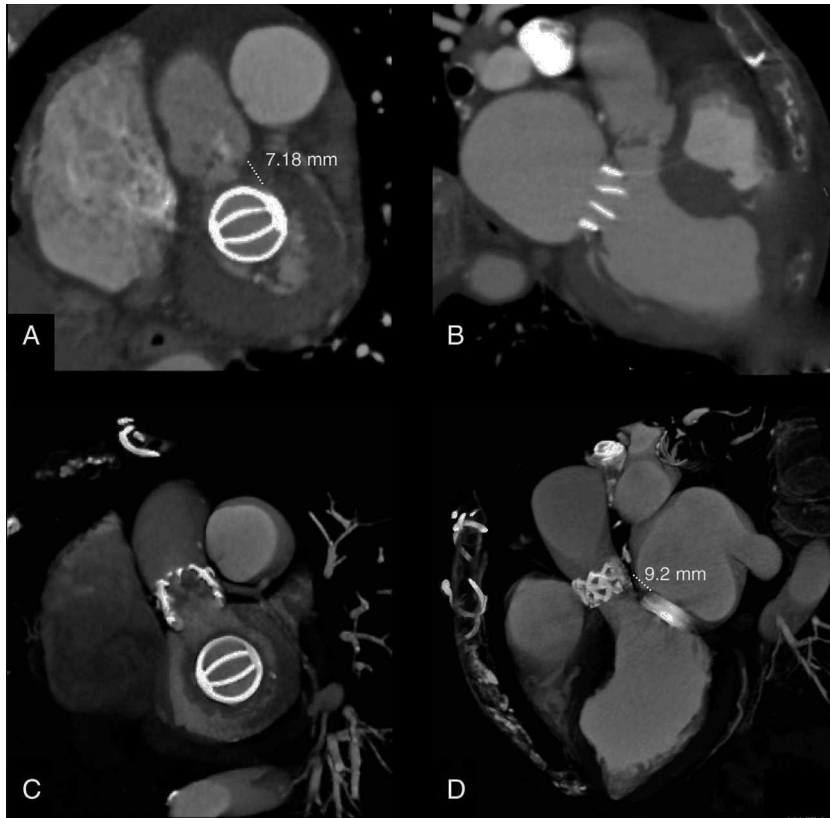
Computed tomography images before (A and B) and after (C and D) implantation.
